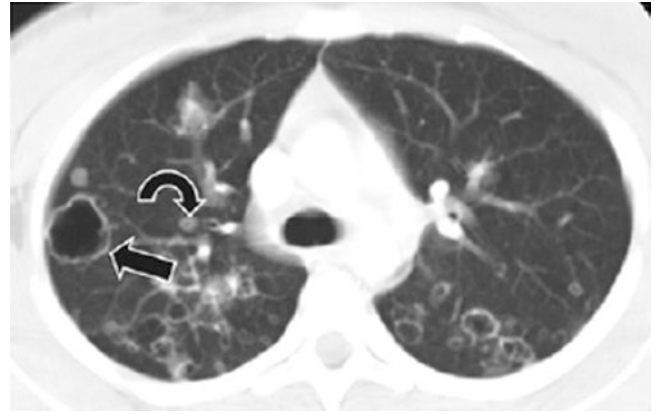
A 17-year-old boy with known papillomatosis. Axial lung window CT image shows a combination of cavitory (*arrow*) and non-cavitory (*curved arrow*) nodules in both lungs
